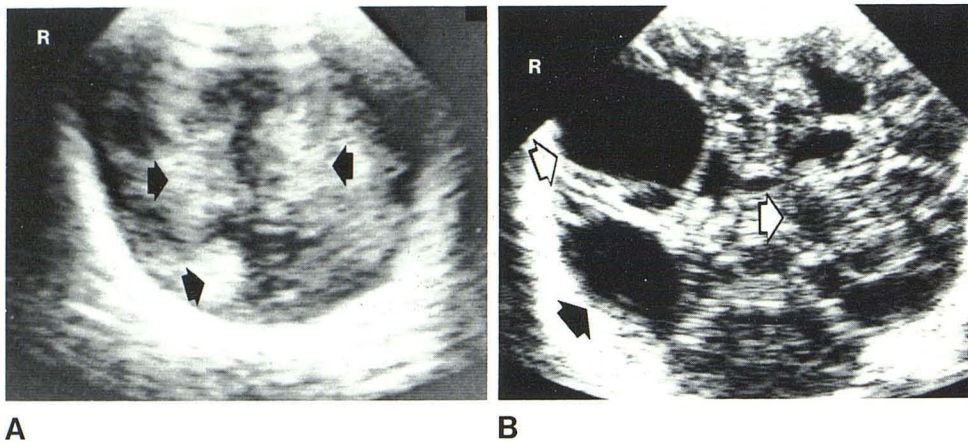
Case 2. Coronal sonograms. A, Severe bilateral intracerebral hemorrhage (*arrows*). B, 6 months later. Irregular asymmetric cavitation (*arrows*) typical of multiple cystic encephalomalacia. Ventricular system is compressed and difficult to see.
